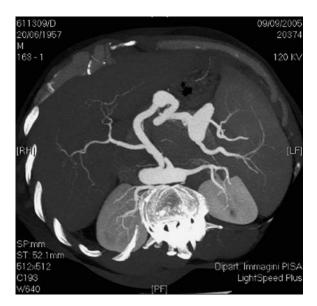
3D-CT angiogram. MIP image shows double splenic aneurism
